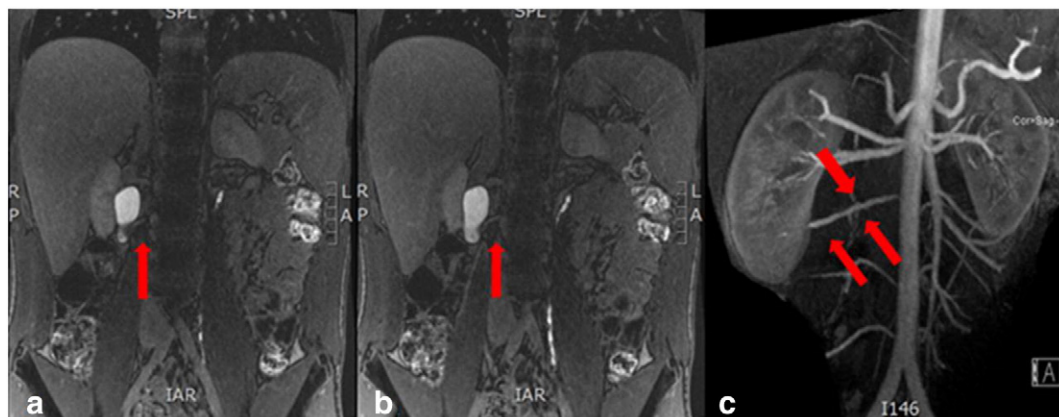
fMRU: A and B: MRI showing the aberrant vessel crossing the right renal pelvis; C: three-dimensional reconstruction.
